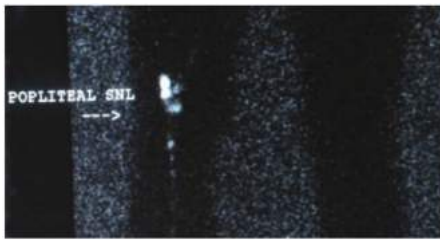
• Lymphoscintigraphy demonstrating lymphatic drainage to the popliteal fossa from a primary melanoma of the distal right foot.
